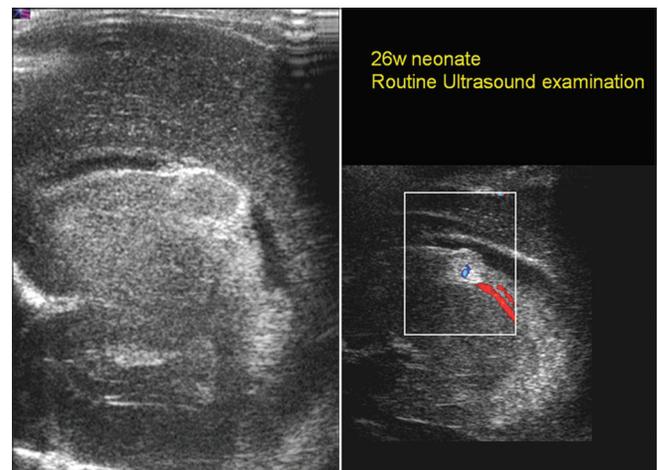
Coronal and sagittal sonographic images demonstrating a grade 1 hemorrhage at the caudothalamic groove
